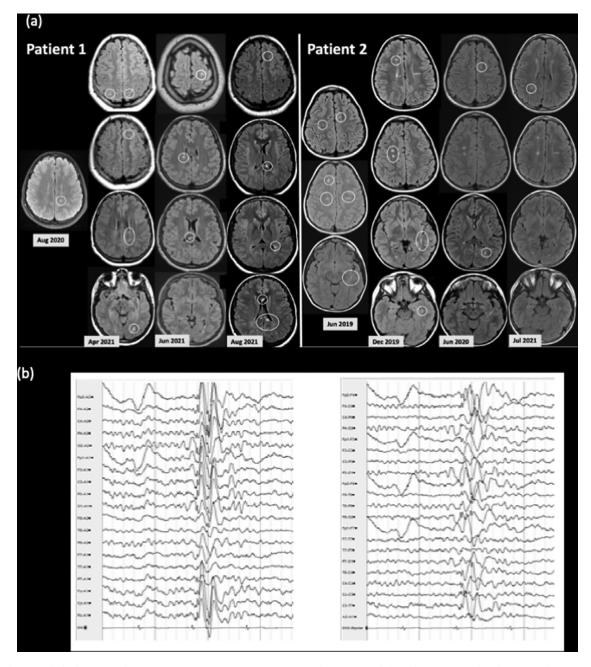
a) Volume axial Fluid-attenuated inversion recovery (FLAIR) MRI Sequences for patient 1 (left) and patient 2 (right) showing T2 hyperintense lesions at baseline and serially on follow up imaging. New lesions on follow-up imaging are encircled. b) Interictal awake and sleep EEG for patient 2 demonstrated normal alert background activity with anterior- posterior gradient. Generalized and fragmentary regular spike and wave activity, maximal over the bifrontal regions, was seen during alertness, drowsiness and hyperventilation which was not accompanied by clinical symptoms.
